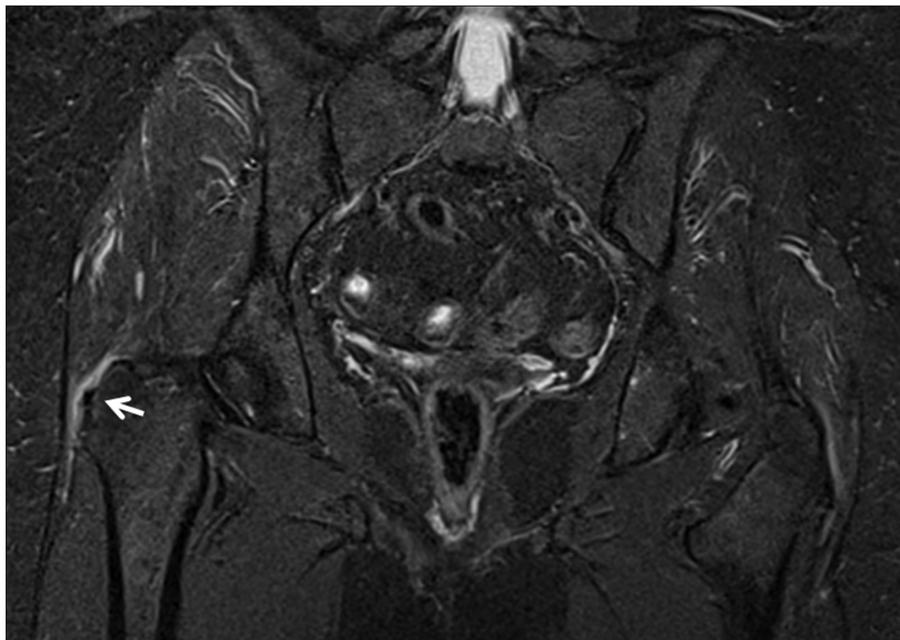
A 56-year-old female patient with right hip pain lasting for six months. The patient received CT-guided treatment twice within a period of four weeks. The coronal short tau inversion recovery (STIR) image shows calcification at the gluteus medius tendon, surrounded by soft tissue edema (arrow).
